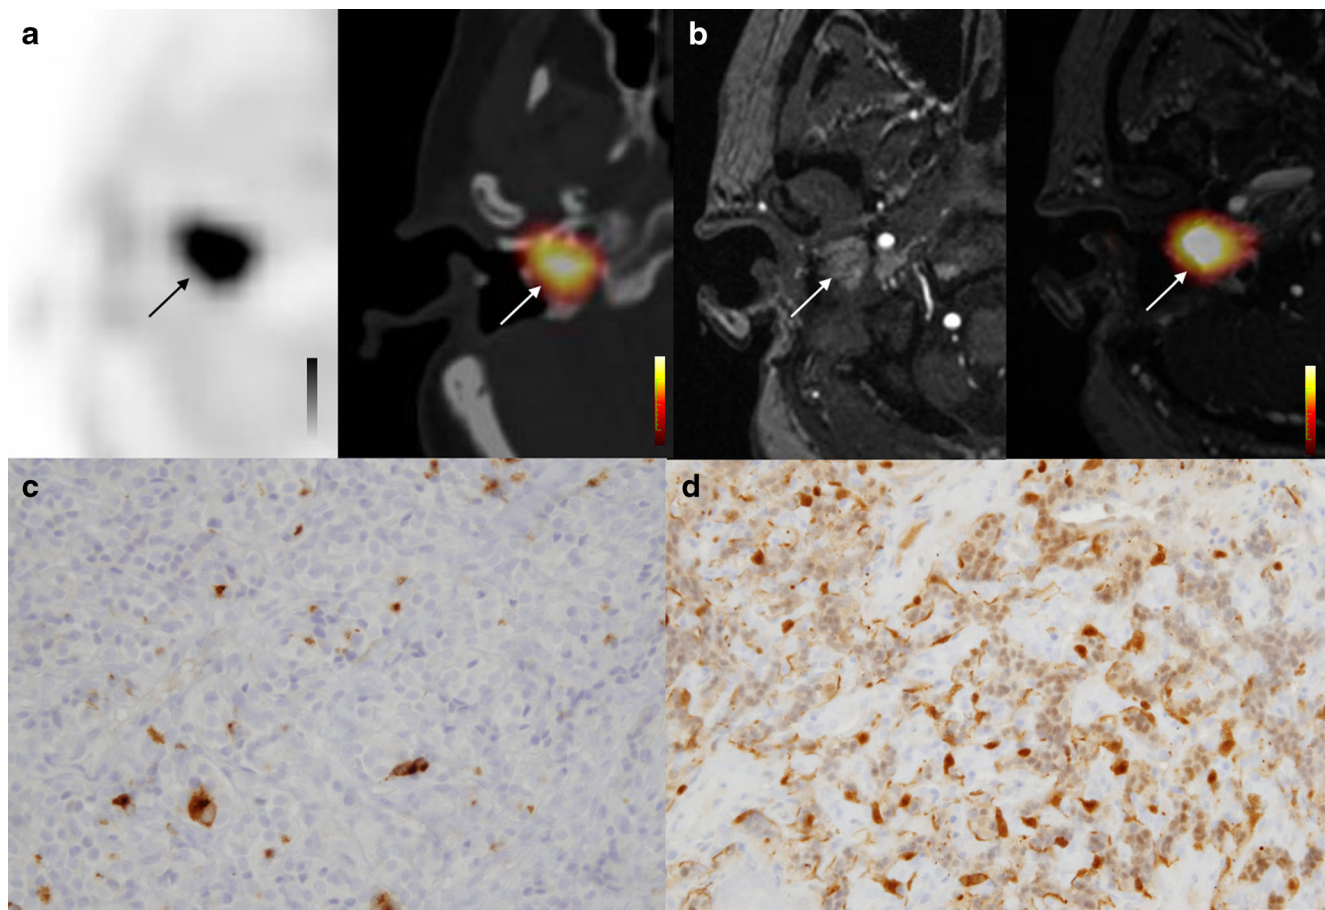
A 41-year-old woman with a recurrent sporadic right jugulotympanic PGL treated by complete surgery (patient 14). a Axial PET and PET/CT images show intense ^{18}F -FDOPA uptake in the recurrent right jugulotympanic PGL. b Gadolinium-enhanced MRA
